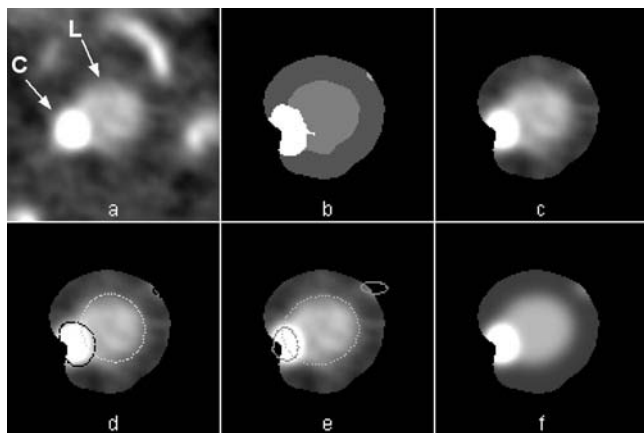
(a) First CTA image in the proximal part of the stenosed segment of patient 1 with calcification (Fig. 9, at 19 mm); the lumen is indicated with an L and the calcification with a C; (b) ROI with initial segmentation of the artery (light grey), border (dark grey), part of calcification within border (white), and very small part of calcification at top right (light gray); the shape of the calcification in (b) does not correspond exactly with that in (a) because of the 3D dilatation in a preprocessing step (see text); (c) ROI; (d) initialization with $N=1$ (ellipse) for the artery, $N=2$ for the calcification, and $N=1$ for the very small part of the calcification at top right; (e) fitted contours and (f) fitted model images, using prior knowledge of I_f , I_b , and σ . (Table VI, patient 1). Use of prior knowledge of I_f and σ only gave virtually the same fit. The window center is 180 HU and the window width is 500 HU for images (a) and (c)–(f). Each image measures 12.8×12.8 mm²
